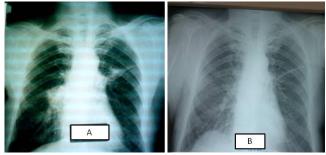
Chest X-ray showing a right lung hilar mass and 2 to 2.5 cm wide shadow like band extending the peripheral region from hilar to the left lung (A). During diagnosis of lung tuberculosis and lung cancer and following treatment for lung TB disease (B)
